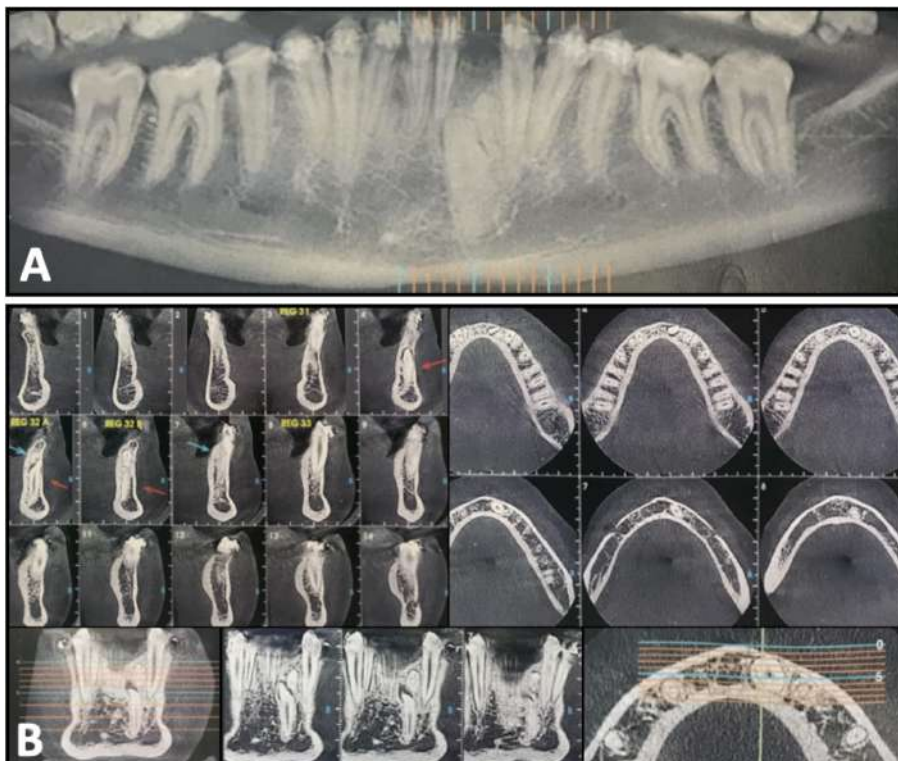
A. Initial panoramic radiograph. B. Cone Beam Computed Tomography scan.
